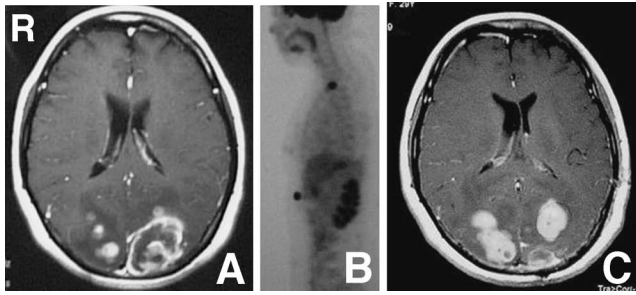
A: Preoperative axial T₁-weighted magnetic resonance (MR) image with gadolinium showing multiple heterogeneously enhanced tumors with edema in the bilateral occipital lobes. B: Fluorodeoxyglucose positron emission tomography scan showing hyper-uptake in the abdominal subcutaneous region and mediastinum. C: Postoperative axial T₁-weighted MR image with gadolinium after first-line chemotherapy showing multiple occipital tumors and the remarkably enlarged residual tumors.
